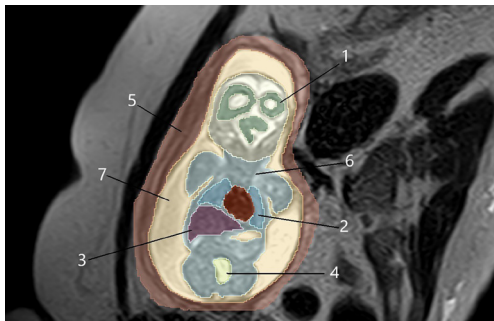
An example of ROIs on coronal T2WI images identified using 3D Slicer software: 1, white matter; 2, lung; 3, liver; 4, bladder; 5, maternal muscles; 6, fetal muscles; 7, amniotic fluid. ROI, region of interest; T2WI, T2-weighted image; 3D, three-dimensional.
